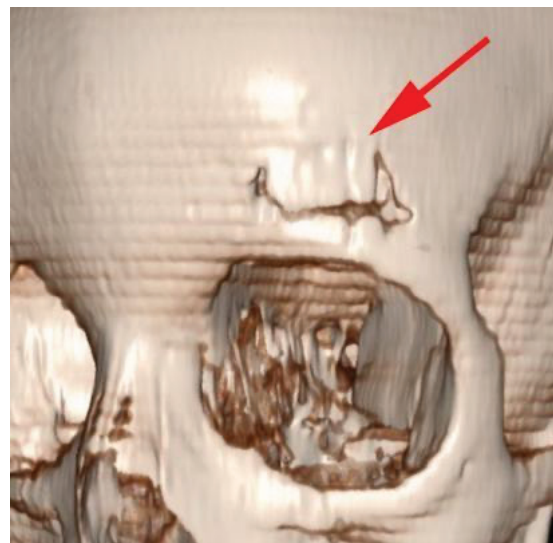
Three-dimensional construction of the postoperative cranial computed tomography scan. Note the small craniotomy (red arrow)
